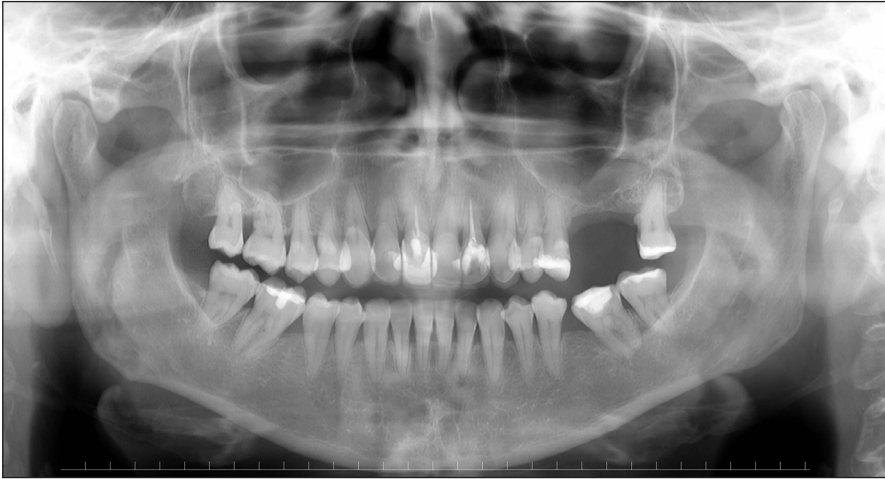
Initial orthopantomograph
